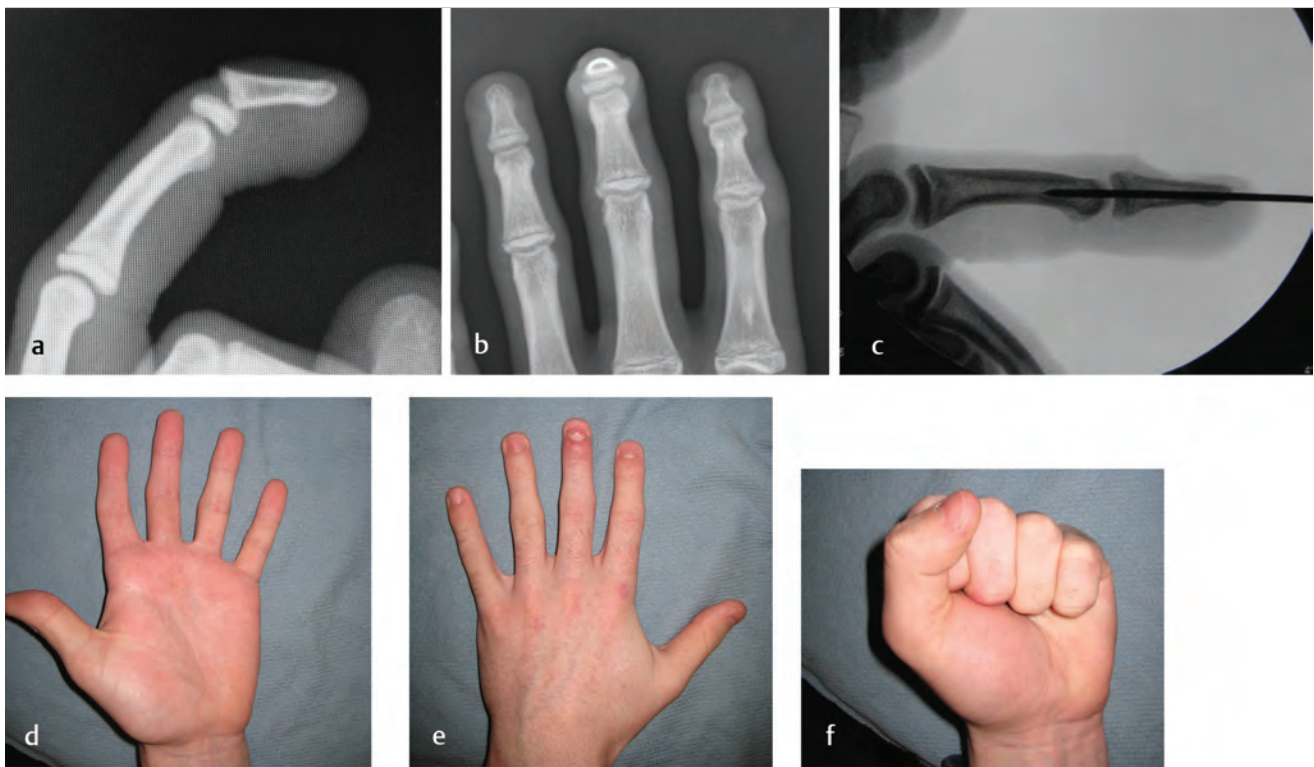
Seymour fracture. The radiographs in (a) and (b) demonstrate a juxtaphyseal fracture which herniates above the nail fold. The nail fold prevents reduction. Lateral incisions in the nail fold (made perpendicular to the nail fold) are usually required to reduce the fracture and a pin secures it (c). Postoperative result in the same patient 2 months postoperatively (d–f) demonstrates normal active range of motion.
